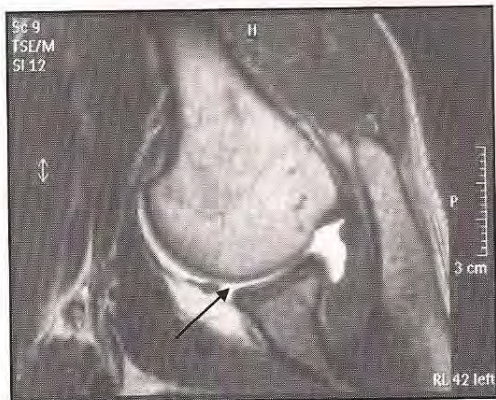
MRI-arthrogram , transversal view, with abrum detachment.
